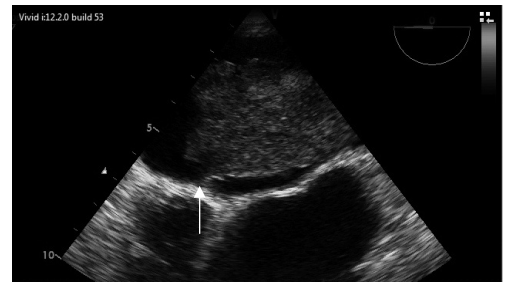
Cardiac myxoma (arrow) attached to the interatrial septum seen on transesophageal echocardiography
